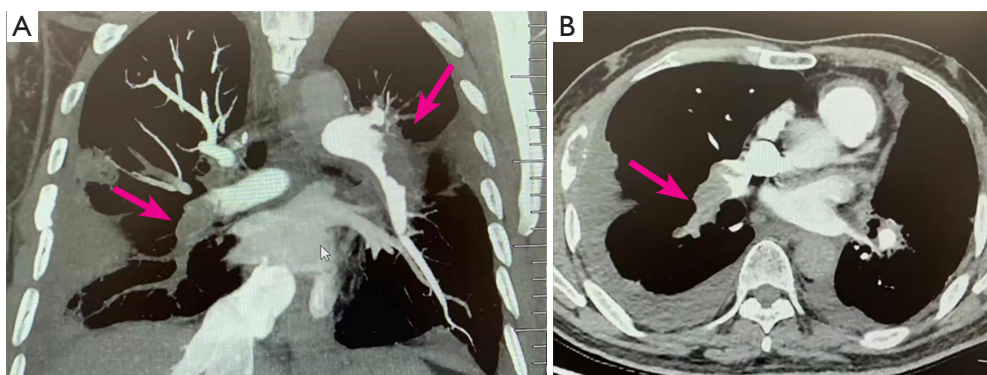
01/2024 pulmonary artery CTA. (A) Coronal view shows filling defects in both the right and left pulmonary arteries. (B) Axial view shows filling defects in the right pulmonary trunk and its branches. Red arrows indicate the location of the thrombus. CTA, computed tomography angiography.
